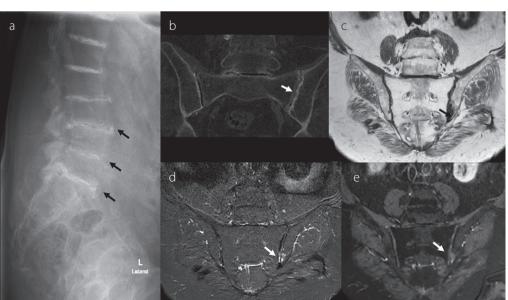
a-e. Radiograph of lumbar spine, showing intervertebral disc calcification and vacuum phenomenon (black arrow) (a). Computed tomography scan of the sacroiliac joints (SIJs) documented joint space narrowing, irregularity, and erosions on the left SIJ (white arrow) (b). Magnetic resonance imaging showed hypointense (c); (T1 weighted) (black arrow) and a hyperintense (d); (STIR) (white arrow) lesions located on the caudal iliac side of the left SIJ. Minimal contrast enhancement was observed in that location (e); (post gadolinium) (white arrow).
